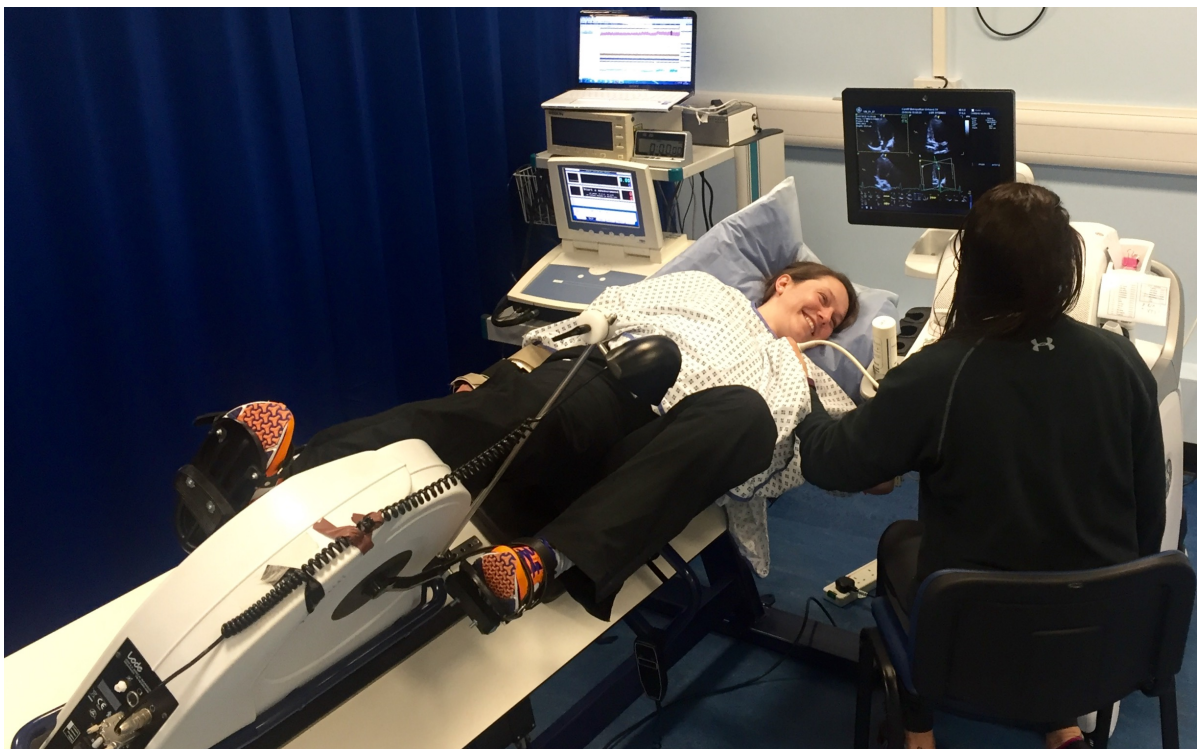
Exercise echocardiography completed on a supine cycle ergometer tilted in the left lateral position. The bed was tilted to between 30 and 45° for all volunteers.
